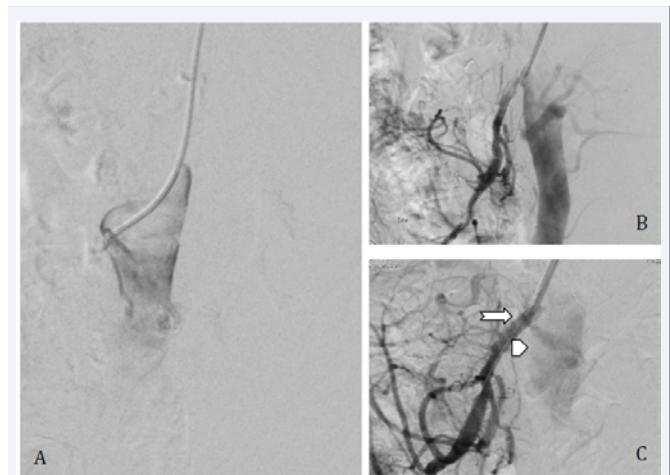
Case 1. A: Angiogram confirming preoperative CTA findings. B: Angiogram after SMA balloon angioplasty. C: Angiogram after the placement of a balloon expandable stent. Note the shadow of the aorta (arrow head) and the position of the stent (arrow).
